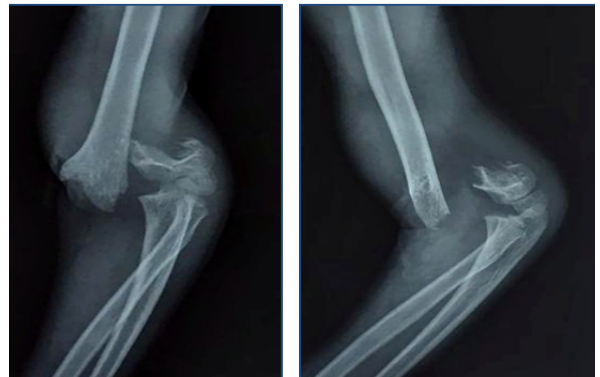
Showing preoperative radiograph of a 10 year old boy with type III supracondylar fracture of left humerus in AP and lateral views planned for closed reduction and crossed pinning.
